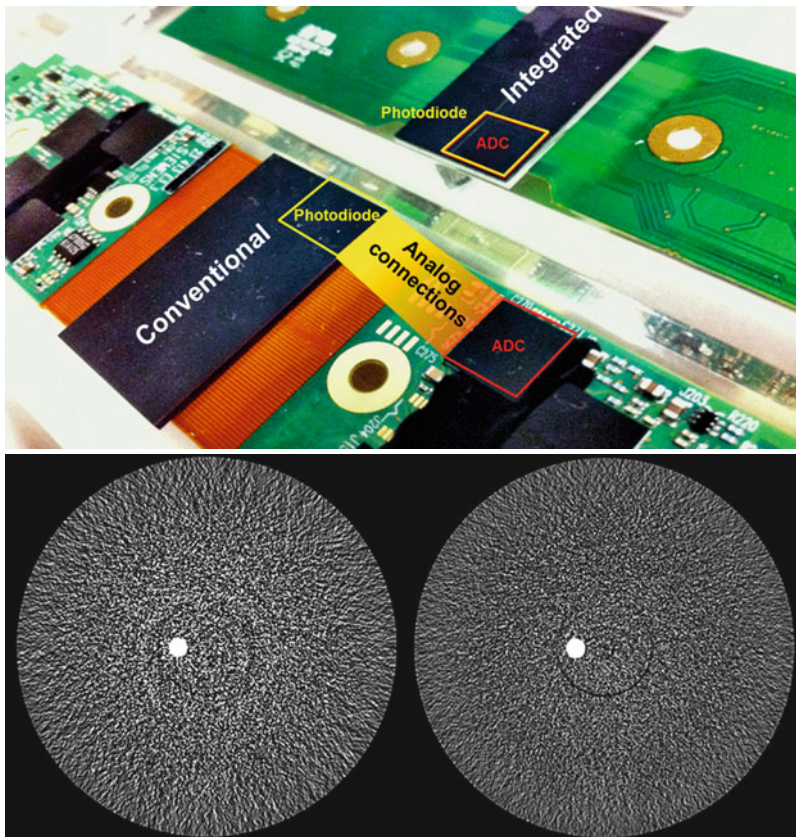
Top*: Principle of an integrated CT detector compared to a conventional CT detector. The Si tile is shown without the scintillation ceramics. Integrated detectors do not use distributed electronics with analog connections. As
